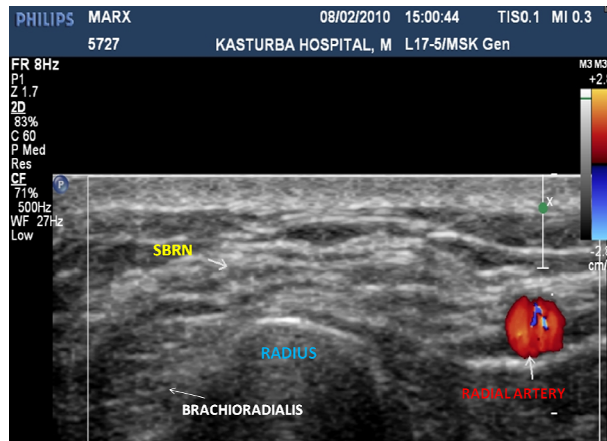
Transversal (short axis) ultrasound image demonstrating the right SBRN and surrounding structures in healthy individual (above wrist). Color Doppler was used to identify the radial vessels (blue and red colored area). SBRN: superficial branch of the radial nerve above wrist.
